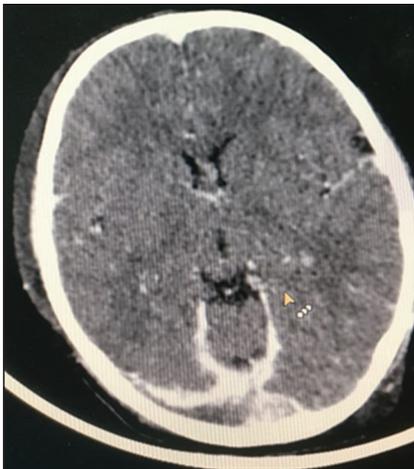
Contrast-enhanced computed tomography brain showing cerebral venous sinus thrombosis and cerebral edema
